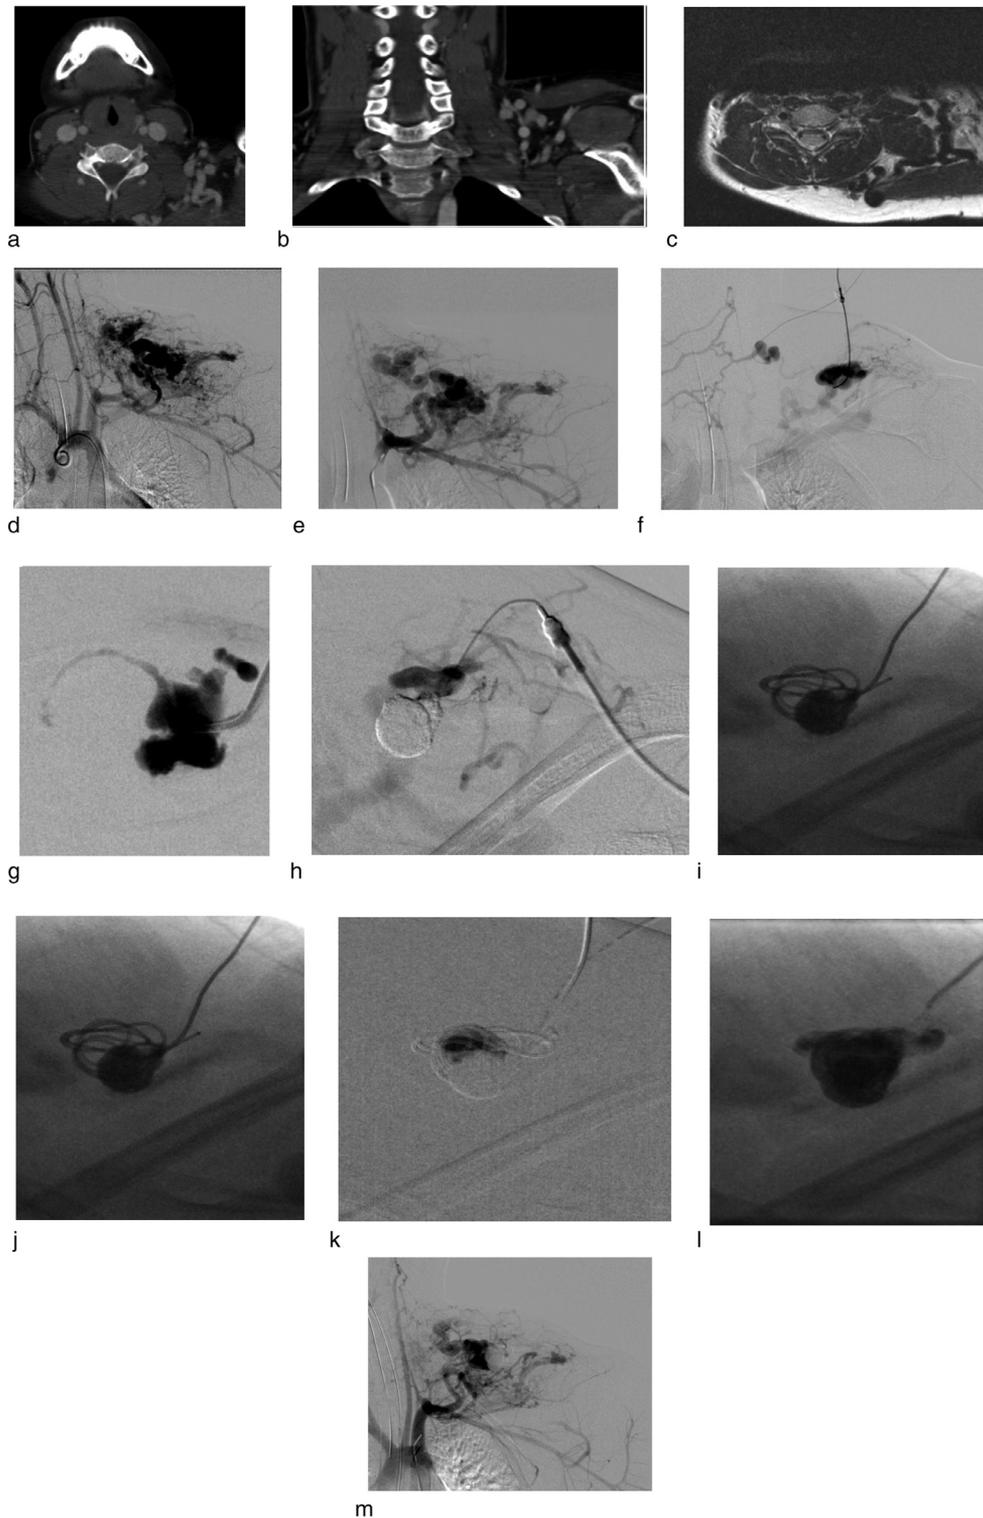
13-year-old male with left supraclavicular AVM. Percutaneous glue embolization of venous outflow was performed via direct injection and also using temporary wire placement as a scaffold for glue. CTA axial (a) and coronal (b) images and axial T1 magnetic resonance (c) image demonstrate enlarged and tortuous vessels in the left supraclavicular region, compatible with AVM. Digital subtraction aortogram (d) and left subclavian arteriogram (e) show left supraclavicular AVM with numerous enlarged draining veins. Ultrasound-guided percutaneous needle access (not shown) of 2 suprascapular draining veins was obtained using 21-gauge EchoTip needles. The needles were exchanged over 0.018 inch nitinol wires for 4 French micropuncture sheaths. Digital subtraction venography via access 1 (f) was performed, followed by glue embolization under negative roadmap fluoroscopic technique (g). Digital subtraction venography via access 2 (h) was performed, followed by temporary deployment of a decored 0.035 inch Bentson wire (i) into the draining vein to serve as a scaffold for glue embolization (j). The wire was then removed (k). Postembolization digital subtraction left subclavian arteriogram showed decreased vascularity of the AVM, with decreased opacification of the nidus and draining veins.
